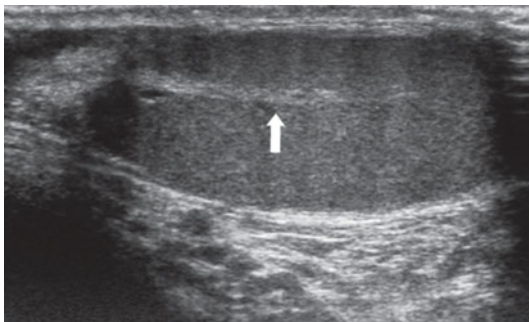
Ultrasonography. Mediastinum testis. The *arrow* indicates a hyperechoic band crossing the testicle, corresponding to the mediastinum testis
